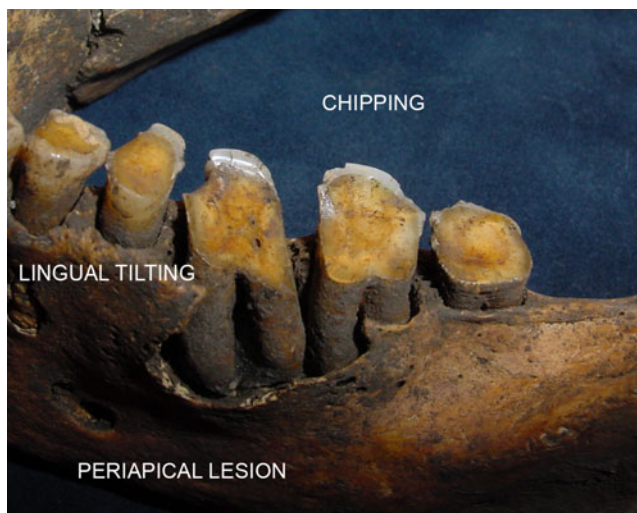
Lower jaw of 40- to 50-year-old male from Ajvide showing a periapical lesion at the first and second molars, lingual tilting of the first molar, and chipping of the premolars and molars. Note also the small aperture of the pulp chamber on the first molar
